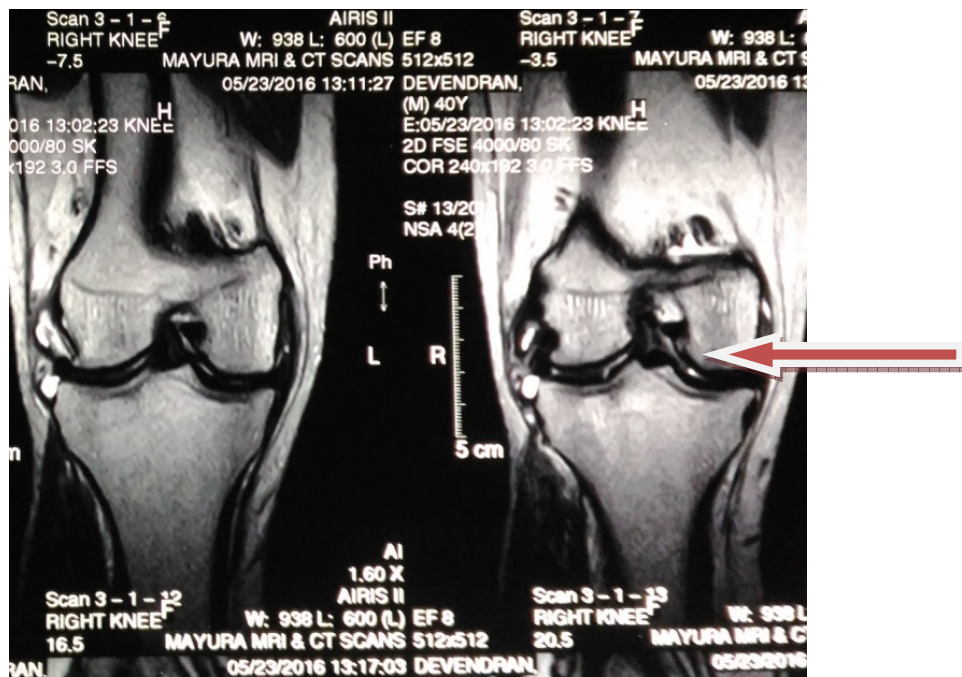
coronal section of MRI right knee showing torn ACL
